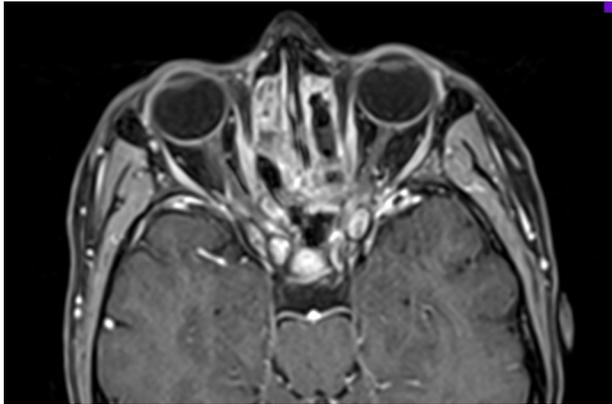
MRI, axial sections, high-intensity appearance of the left optic nerve in the orbital apex.
